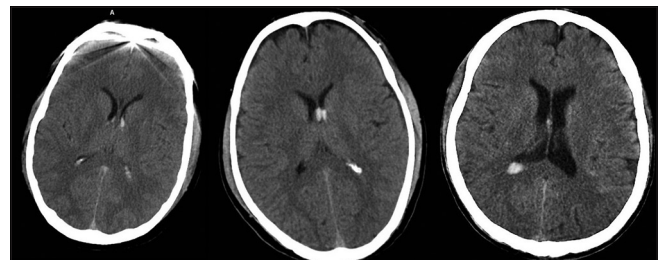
Hyperdense intraventricular hemorrhage seen in both the lateral ventricles with no apparent brain parenchymal changes in various computed tomography images
